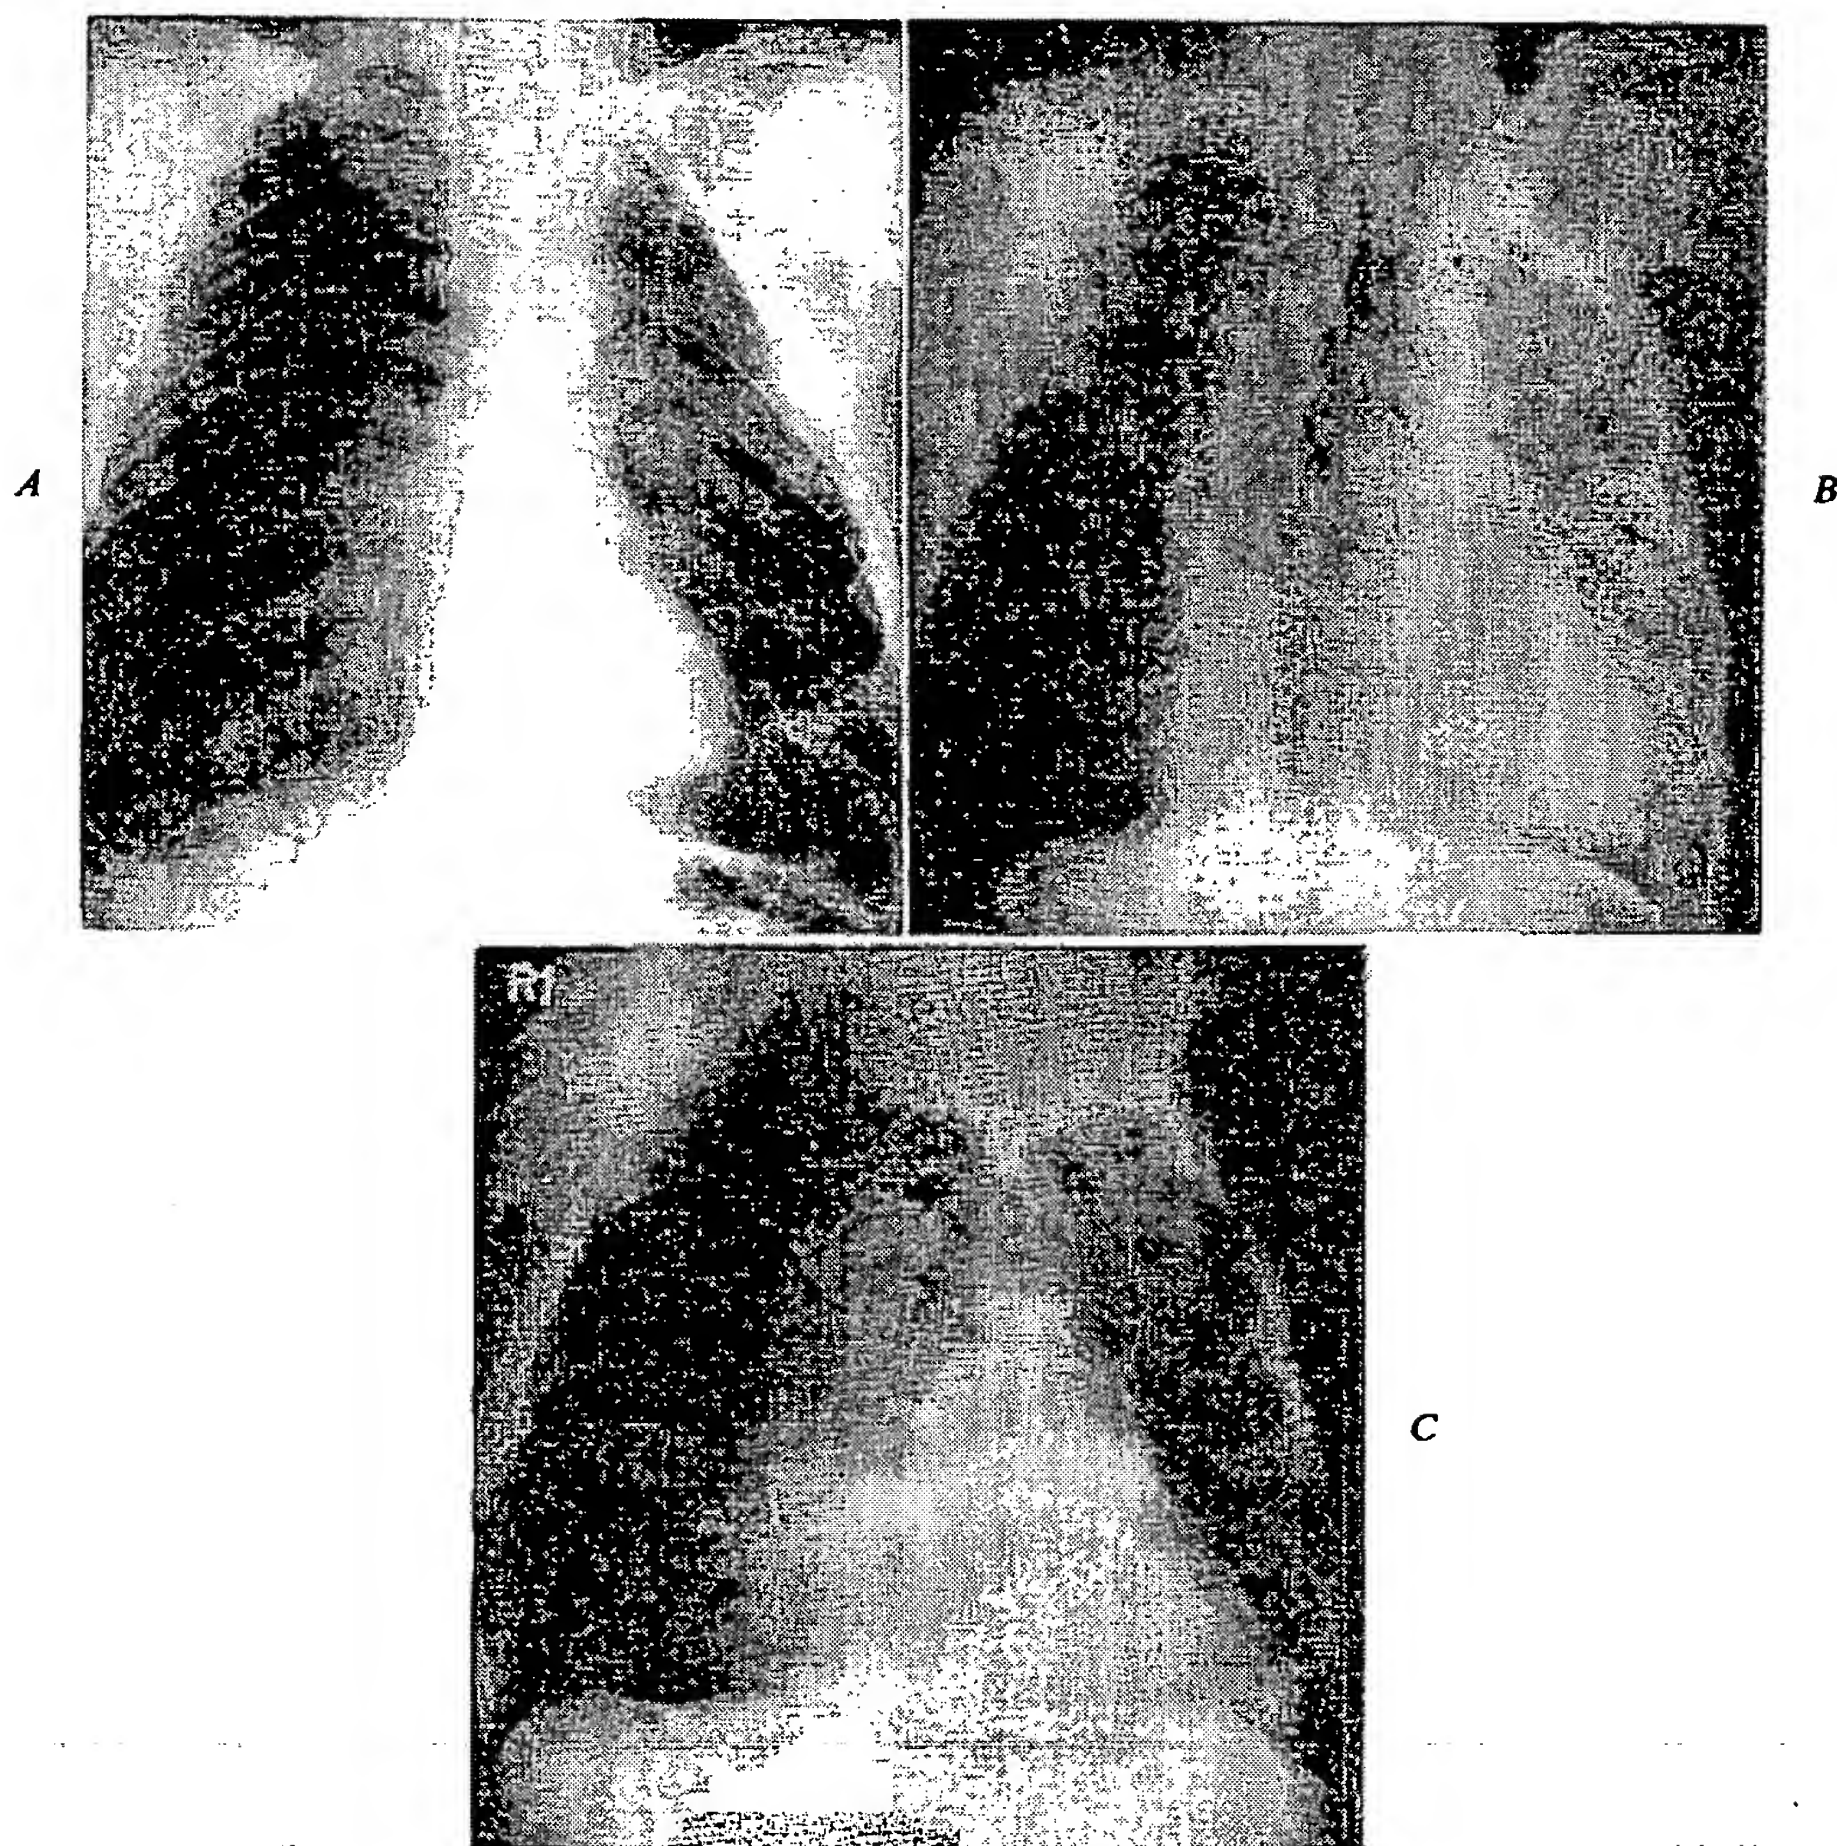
A*, Posteroanterior chest x-ray film shows diffuse emphysema bilaterally. *B*, Oblique x-ray film demonstrates large bulla in the posterior portion of the right lower lobe. *C*, X-ray film made after 2-stage external drainage of bulla shows expansion of previously compressed lung.
